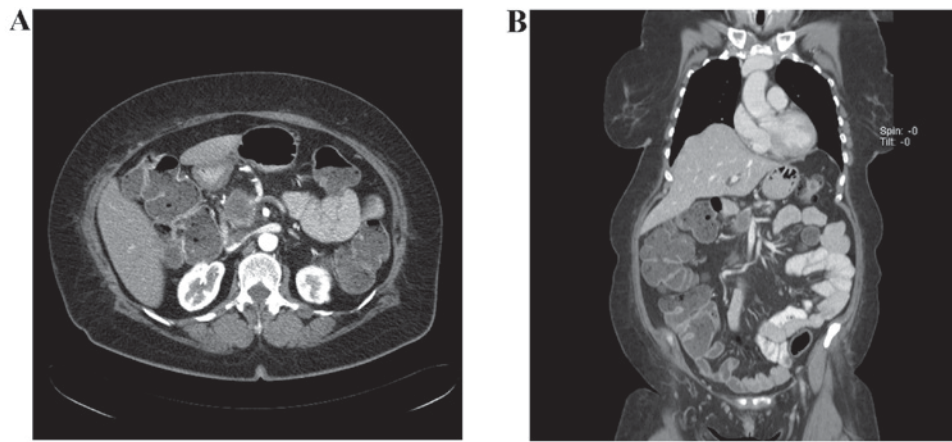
(A) Axial plane and (B) coronal plane computed tomography scan prior to neoadjuvant chemotherapy, showing radiological signs of a borderline resectable lesion: e.g. Encasement/short segment occlusion of the superior mesenteric vein and tumor abutment of the superior mesenteric artery.
